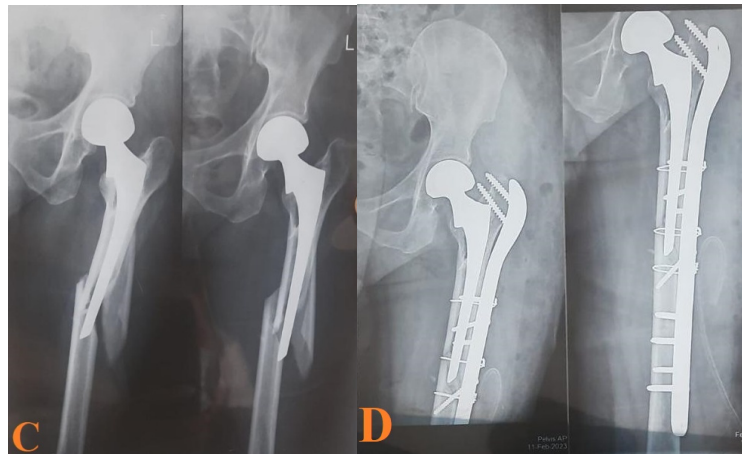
Pre-OP (C) and post-OP (D) x-ray of Vancouver B2 fracture treated successfully by ORIF with plating, cerclages and bone grafting
